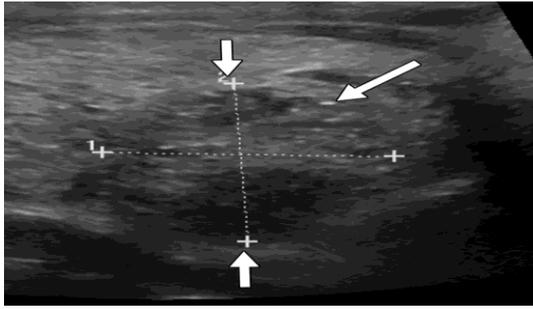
Transverse USG images shows 2 cm solid nodule in right lobe of thyroid in 50 years old women showing numerous punctate echogenic foci in the nodule. Color doppler image revealed lack of flow in the nodule.
